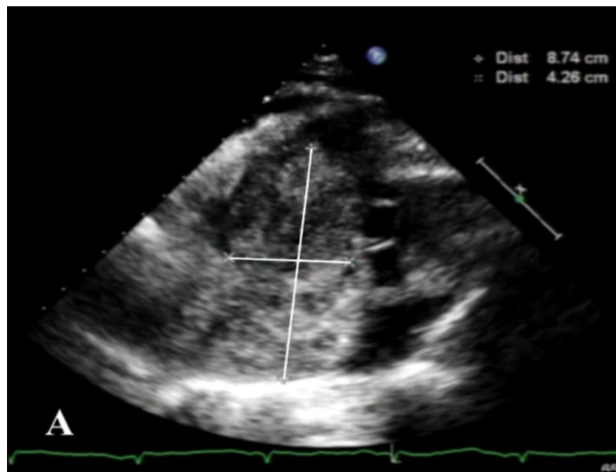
2D echocardiography revealed a right atrial mass suggestive of myxoma measuring 8.74 x 4.26 cm and extending into the inflow of the right ventricle with further prolapse during diastole.
